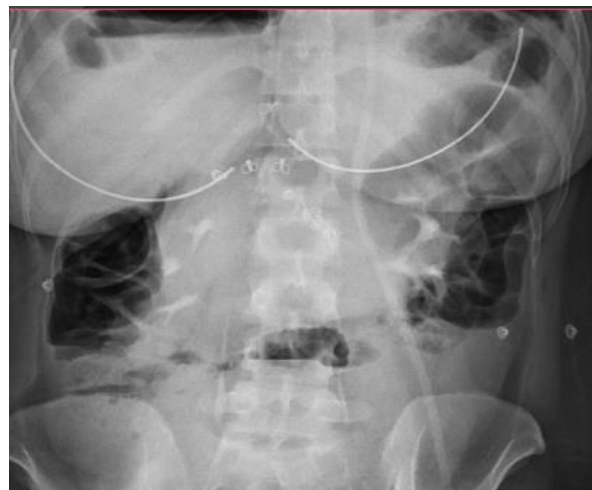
Intensive gas shades at the abdominal x-ray/
